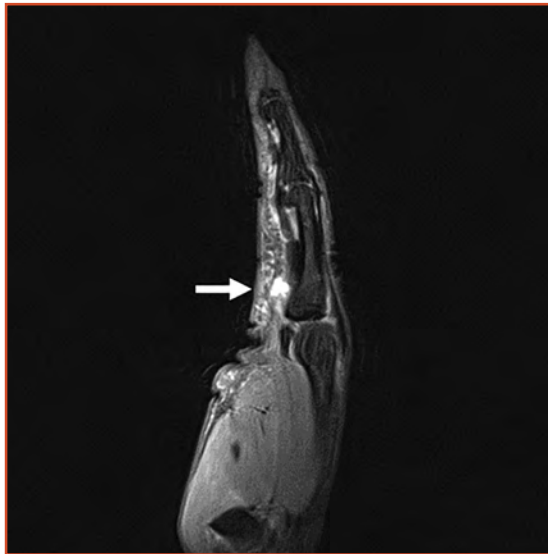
Magnetic resonance imaging of sagittal view depicting the location of the synovial cyst (white arrow) in the region between the A2 and A3 pulleys. There is also increased signal intensity around the tendon corresponding to the fluid and synovitis seen intraoperatively.
